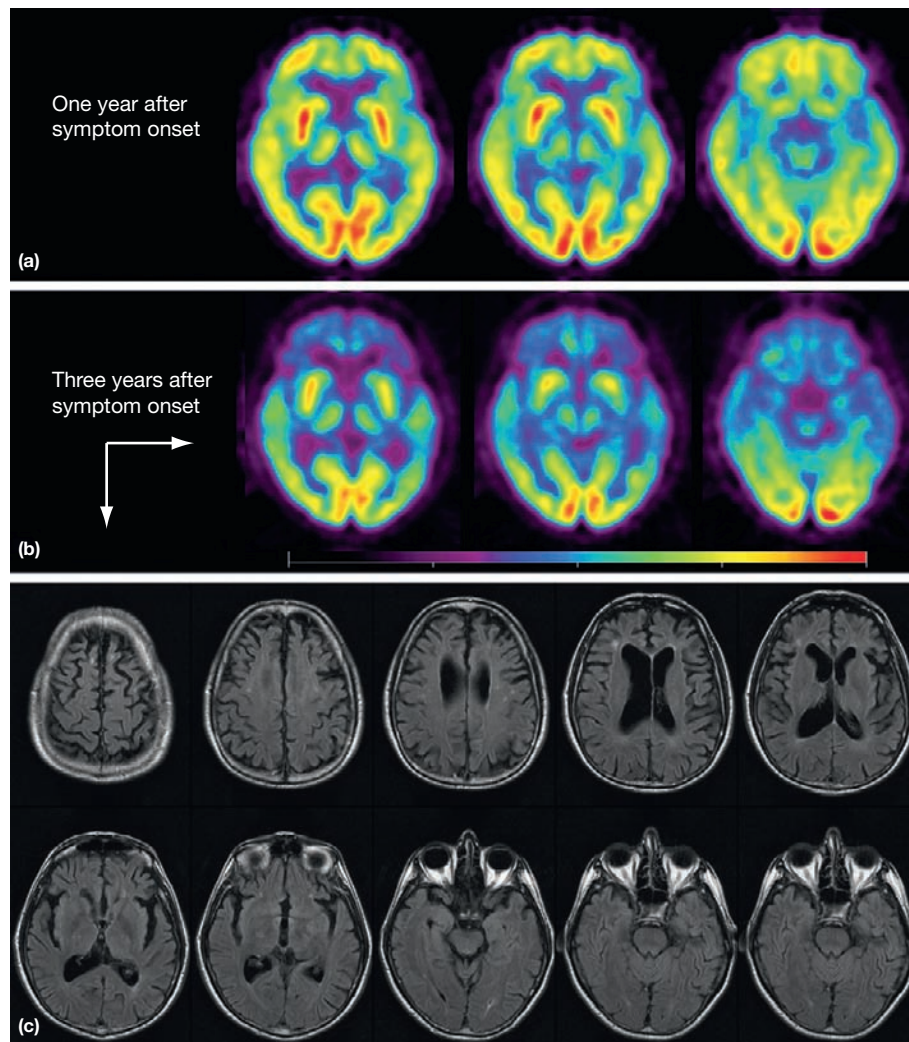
Frontotemporal dementia. Shown are FDG-PET (a, b) and FLAIR MRI (c) studies from a 51-year-old man with progressive speech apraxia and impaired planning, to the point of mutism and complete dependency for activities of daily living when studies (b) and (c) were obtained, taken on the same day. Metabolism was already decreased on the initial PET study, particularly on the frontal opercula and temporal tips, but it is much more obvious on the follow-up study, showing extensive frontotemporal hypometabolism. Note that the frontotemporal abnormality is much more obvious on the PET study (a, b) than on the MRI study (c), which shows frontal atrophy.
